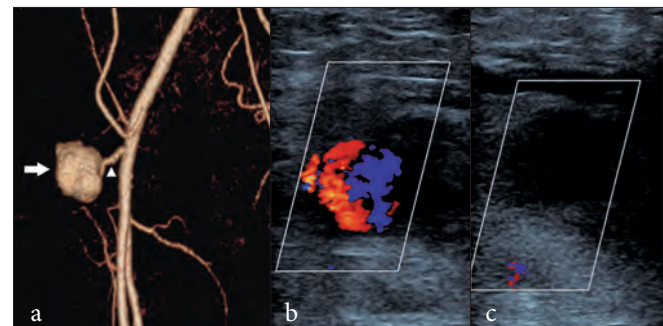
A pseudoaneurysm (closed arrow), with a thin longitudinal neck (arrowhead), is seen adjacent to the common femoral artery and is well depicted on (a) 3D reformatted CT. Note the typical yin-yang sign indicating turbulent flow on (b) ultrasound doppler evaluation. This aneurysm was treated successfully with thrombin injection with complete haemostasis on follow-up ultrasound evaluation, as noted by (c) the lack of duplex Doppler signal.
